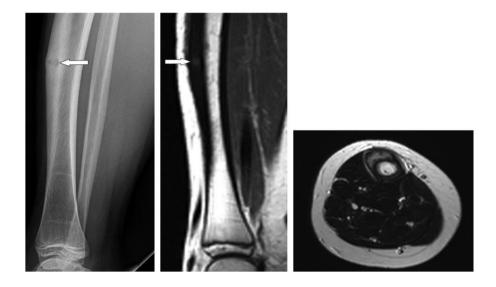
Tibial stress fracture - Lateral radiograph of the left leg reveals mild tibial bowing, with adjacent cortical thickening, and raindrop like a radiolucent lesion (arrow) with tiny central calcification. Sag T1WI MR shows the hypointense lesion (arrow) with thickened cortex. Axial T2WI MR reveals the irregular shape of the lesion (4).
